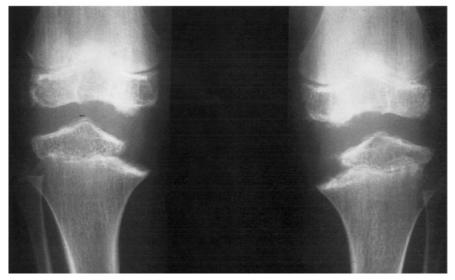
Radiographic features of MED. The ossification centers of the proximal femoral epiphyses (\mathbf{A}) and the distal femoral and proximal tibial epiphyses (\mathbf{B}) are flattened and irregular in contour, with delayed ossification.
